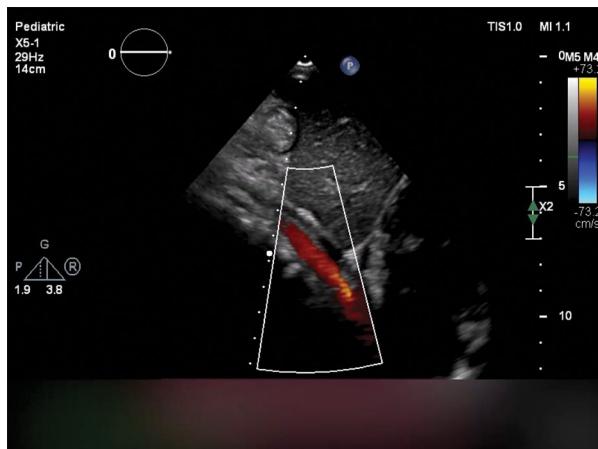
Echocardiographic study – continuous, non-pulsatile flow in the abdominal aorta
